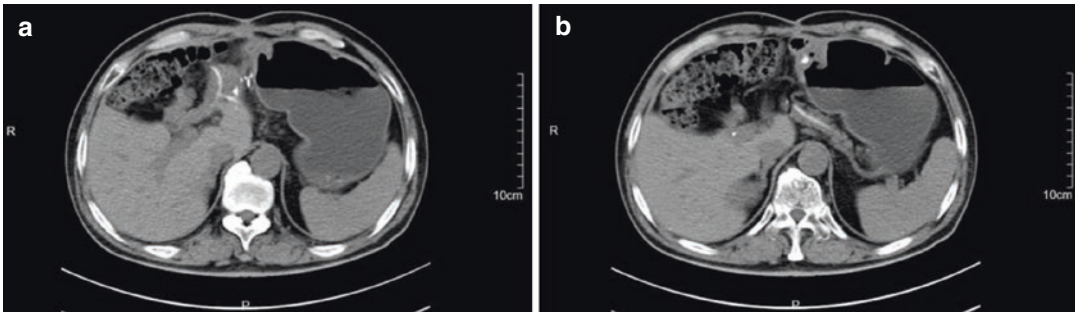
(a, b) CT plain scan shows stent in the re-PJ anastomosis
